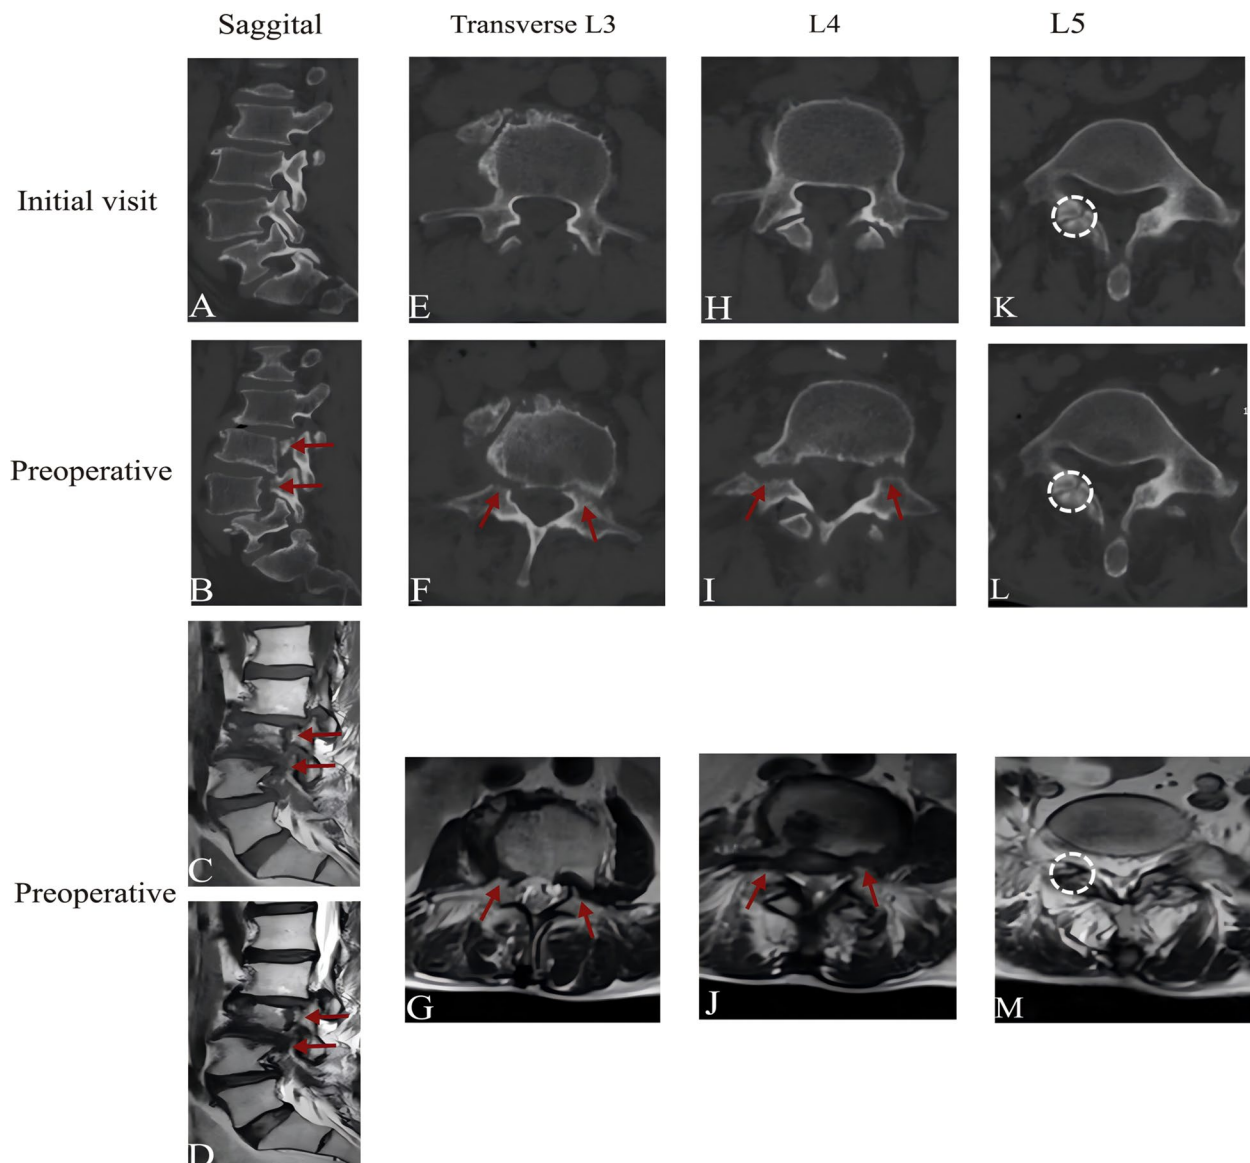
CT scan at the initial visit confirmed intact pedicles at L3 and L4 (A/E/H) and defects in the right isthmus at L5 (K, white circle). The preoperative CT revealed bilateral pediculolysis of L3 and L4, hyperplasia and sclerosis around the defect (B/F/I, red arrow), and hyperplasia and sclerosis at the right isthmus end of L5 (L, white circle). On preoperative MRI, sagittal T1- and T2-weighted images revealed hypointensity at the pedicle cleft (C/D, red arrow), cross-sections with hypointensity at the defect (G/J, red arrow), and a right isthmus with hypointensity (M, white circle)
